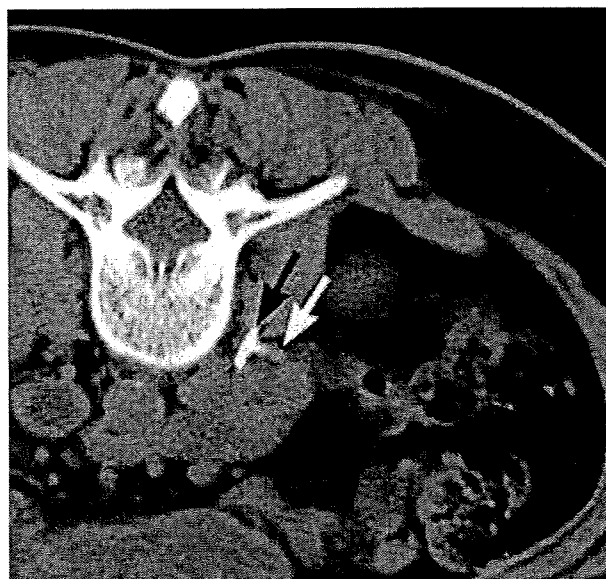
Under computed tomography (CT) guidance, a 15-cm 21-gauge long elastor needle was inserted into the inferior vena cava (IVC) (black arrow) in a 60-year-old woman. After confirming the location of the right urinary tract (white arrow), caution was exercised to avoid it
